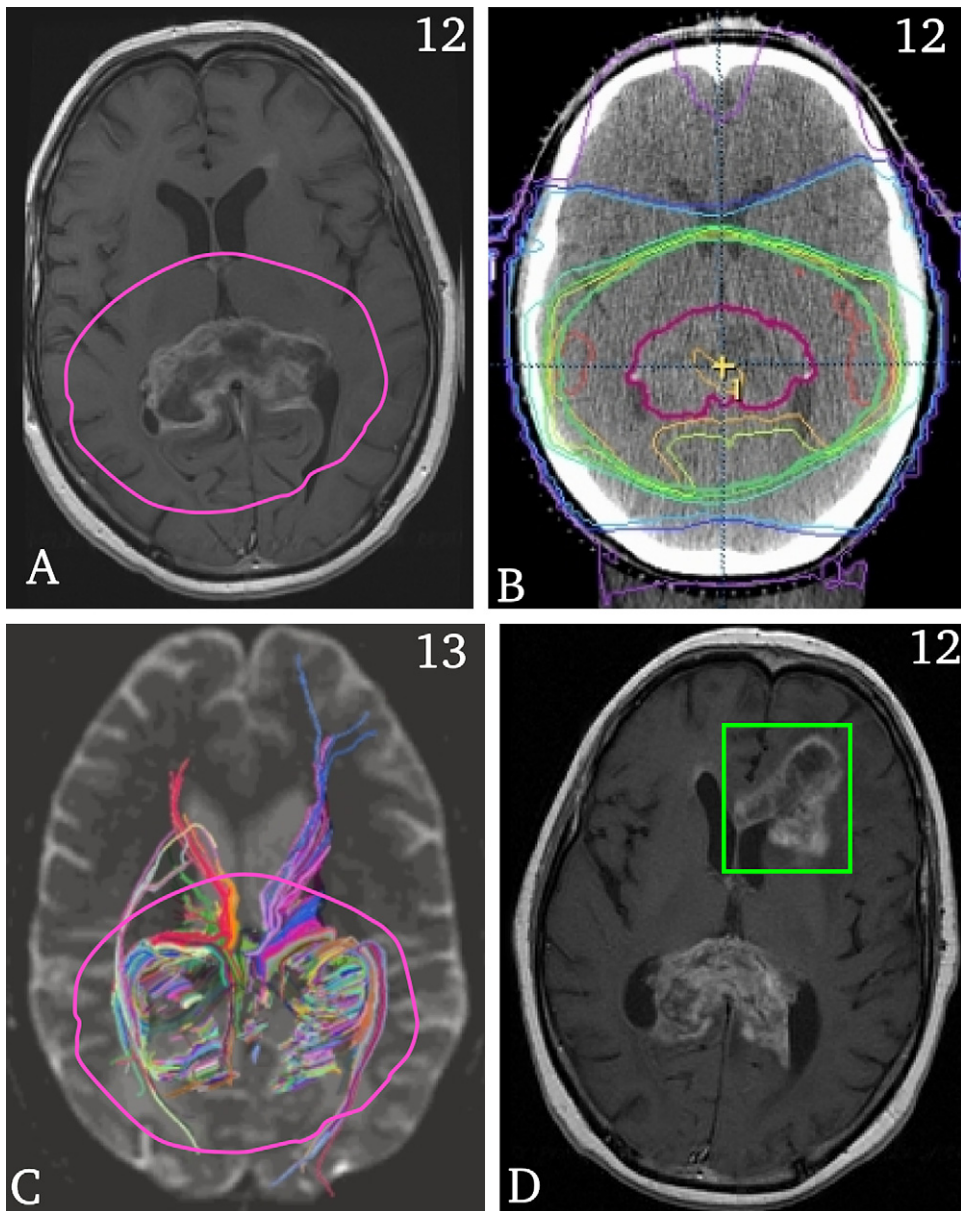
(A) T1 weighted postcontrast magnetic resonance image acquired 6 months after SRT showing a previously stereotactic radiotherapy treated primary glioblastoma multiforme (GBM) in the splenium of corpus callosum. (B) Treatment margins of the primary GBM overlaid onto the computed tomography planning image. The 90% isodose volumes are shown by pink lines on other images (light green in this image and pink in C). (C) Diffusion tensor imaging reference image ($b = 0$) at the same time point of (A) showing all the tracts from the primary tumor projected on the two-dimensional plane, as determined using DTIStudio. Tracts do not course significantly superoinferiorly. Four bundles of tracts pierce the treatment margin, where the two most prominent correspond to the inner capsules. (D) T1 weighted postcontrast image of the secondary tumor (green box) 3 months after the time point of (A), which occurred along the most prominent piercing tract in (C).
